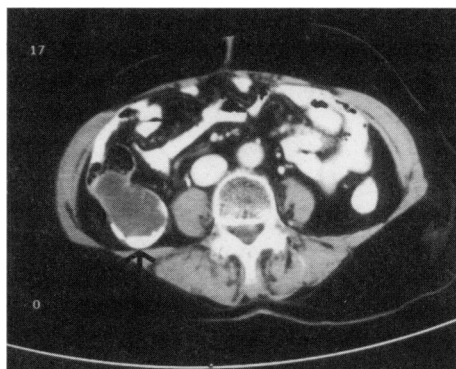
Abdominal CT scan shows a cystic well-encapsulated lesion with curvilinear calcified wall in right lower quadrant and indenting the cecum
